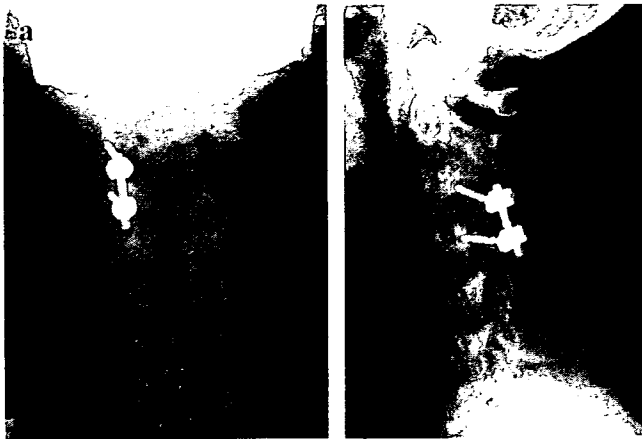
a, b, Postoperative radiography of the cervical spine. C3–C4 posterior spinal fusion was performed using unilateral lateral mass screw system after subtotal extirpation of the tumor.
